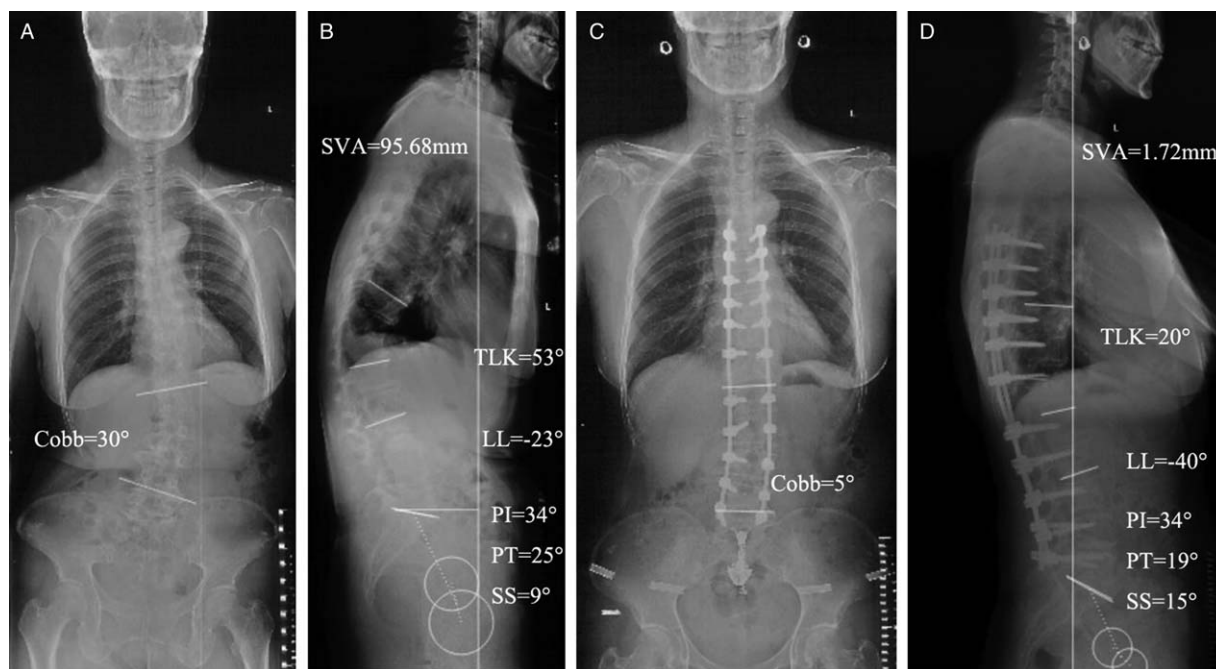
A 58-year-old female with Lenke-Silva level VI degenerative scoliosis was treated with long-segment decompression/fusion and osteotomy. Pre-operative anteroposterior (A) and lateral (B) X-ray indicated lumbar Cobb angle = 30°, SVA = 95.68 mm, LL = -23°, PT = 25°, PI = 34°, SS = 9°, and TLK = 53°. Post-operative anteroposterior (C) and lateral (D) X-ray showed the fusion segments of T10-L5 and osteotomy of T12, lumbar Cobb angle = 5°, SVA = 1.72 mm, LL = -40°, PT = 19°, PI = 34°, SS = 15°, and TLK = 20°. SVA: Sagittal vertical axis; LL: Lumbar lordosis; PT: Pelvic tilt; SS: Sacral slope; PI: Pelvic incidence; TLK: Thoracolumbar kyphosis.
